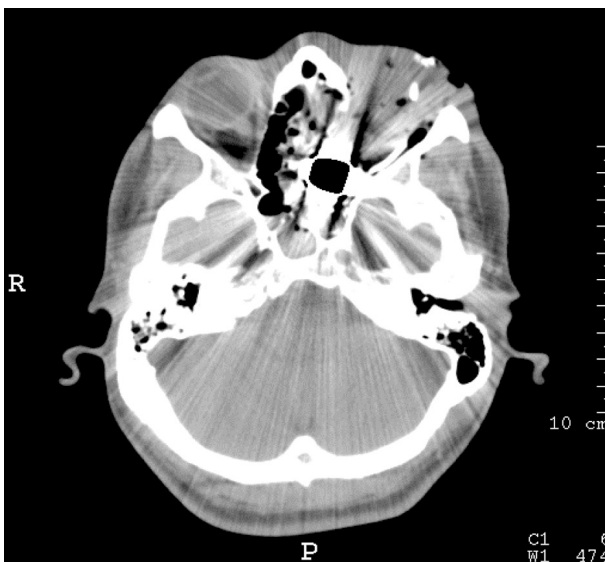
Computed tomography scan of 18 year-old man with penetrating ocular rubber-bullet injury
